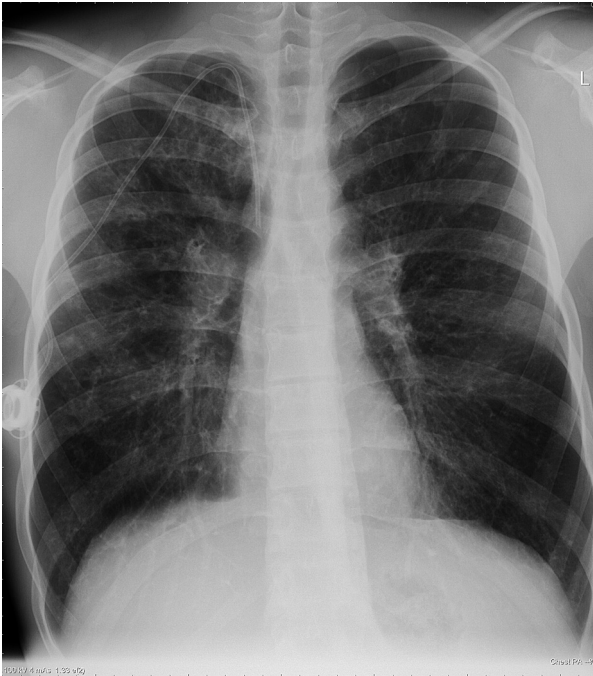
Typical chest radiograph of a patient with CF demonstrating bilateral generalized bronchial wall thickening, tram-lining indicating bronchiectasis, and the presence of a TIVAD in the right hemi-thorax.
